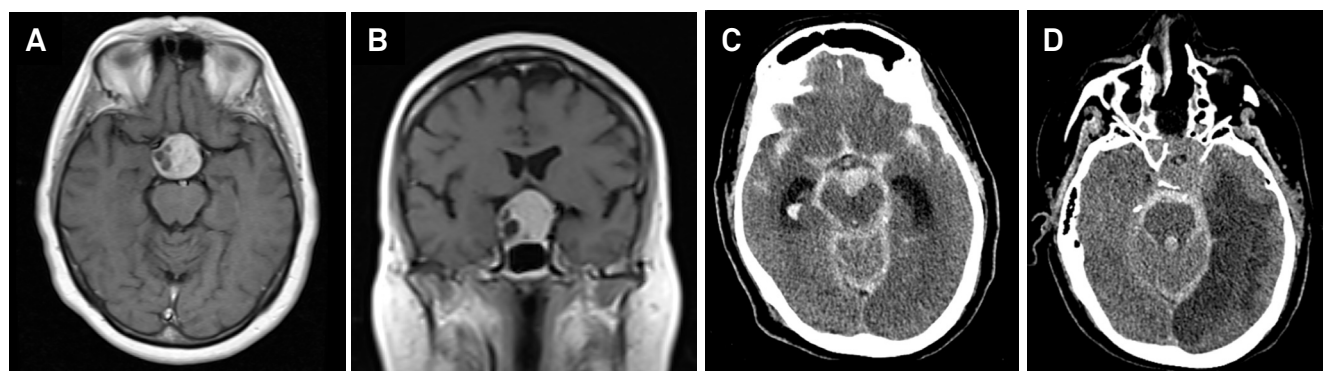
Preoperative axial (A) and coronal (B) T1-weighted gadolinium-enhanced MRI of a rounded giant pituitary tumor. (C, D) The patient underwent near-total resection of the adenoma, but experienced a severe subarachnoid/tetrahentricular haemorrhage after cavernous sinus violation and internal carotid artery injury, which ultimately lead to diffuse cerebral vasospasm and brain death.
